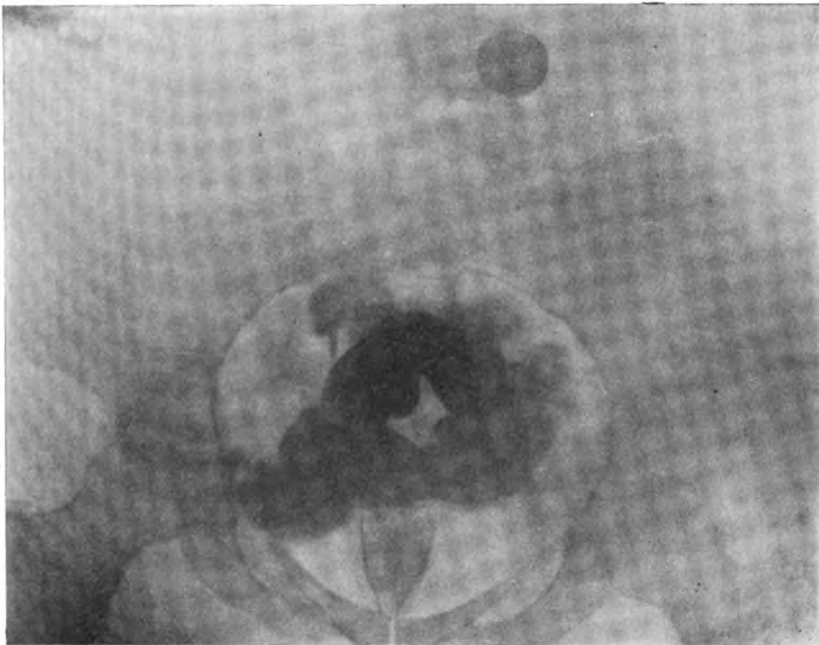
Radiograph of rectum and sigmoid flexure.
